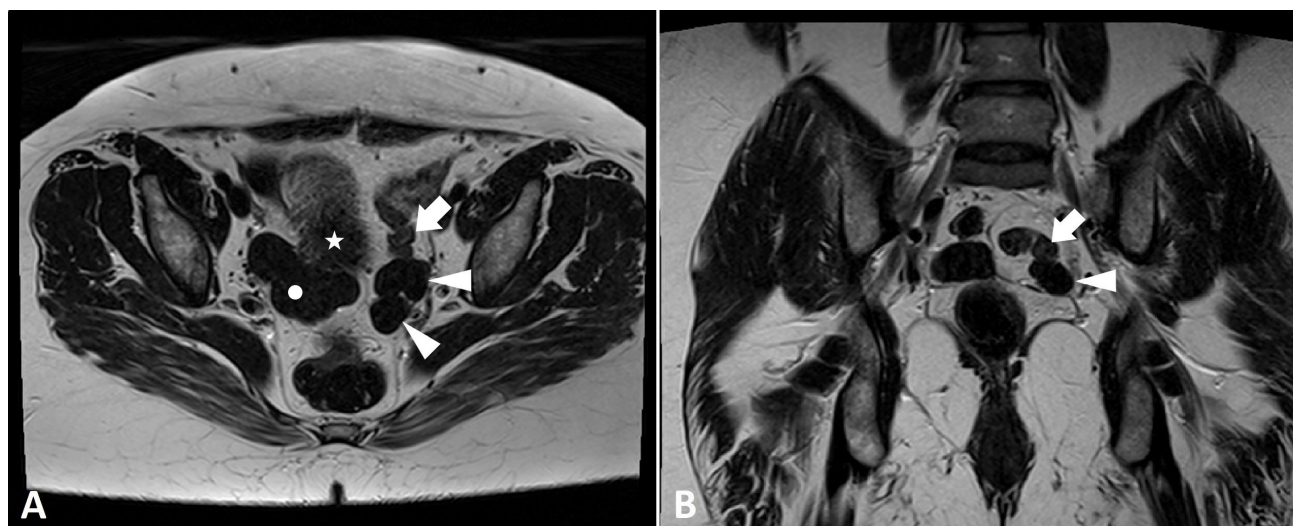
Parasitic leiomyoma. (A) Pelvis magnetic resonance imaging scan on the axial plane (T2-weighted sequence) showing, in another patient, two intra-peritoneal parasitic leiomyomas in the left iliac fossa (arrowheads), one of which is adherent to a small bowel loop (arrow); both of the aforementioned formations are clearly separated from the uterus (star), which is only partially included in this slice and is affected by multiple conglomerate sub-serosal leiomyomas (dot). (B) A coronal sequence on the same patient better highlights the strict relation between one of the parasitic leiomyomas (arrowhead) and the wall of the small bowel (arrow), from which the myoma probably sustain itself.
